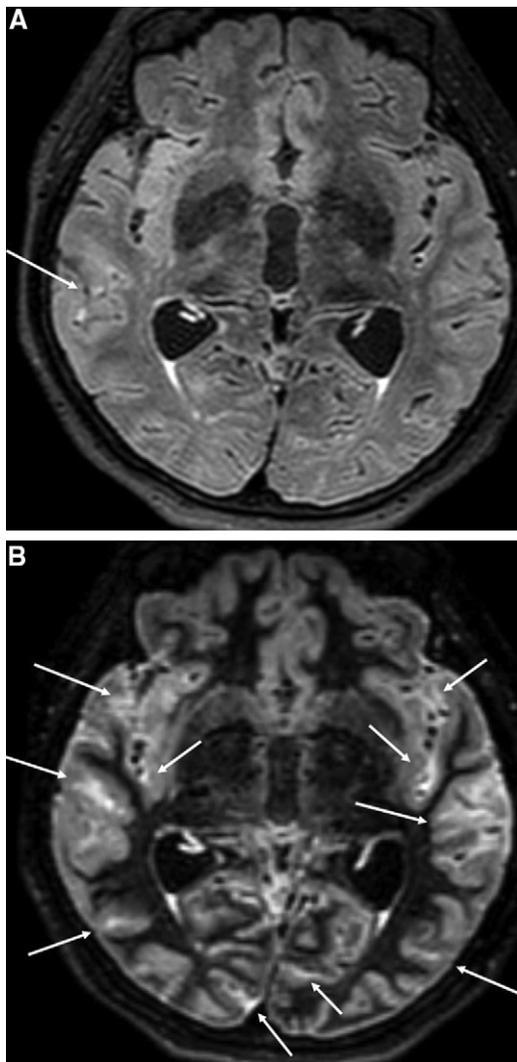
A 66-year-old woman with subacute SAH (13 days after onset). (A) 3D FLAIR and (B) 3D DIR images showing subacute SAH. The SAH lesion is more clearly and extensively visible on the 3D DIR image than on the 3D FLAIR image (arrows A and B).
